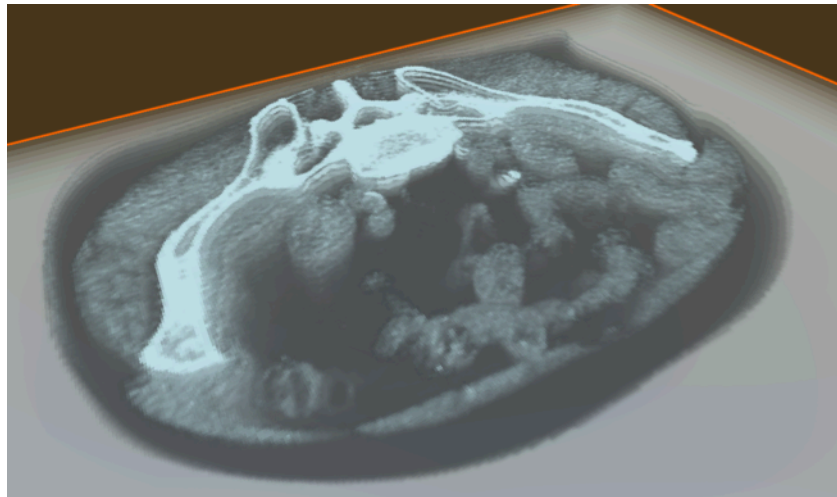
Pseudo volume rendering; 8 semitransparent CT slices are rendered with transparency decreasing form the top to the bottom (top). Use of spotlight Unity game object to control contrast/luminosity of CT dataset rendering without low-level data processing (bottom). The blue object is the HoloLens gaze cursor.
